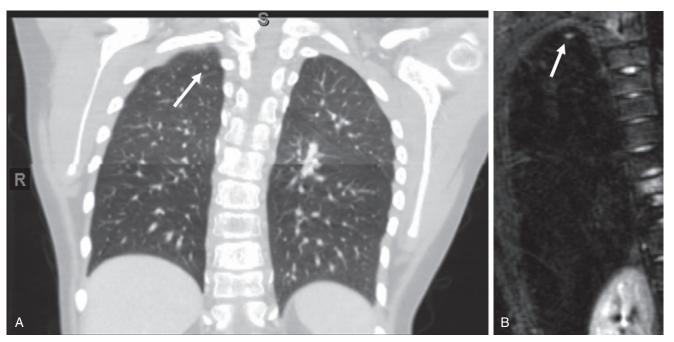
Eleven-year-old with metastatic rhabdomyosarcoma. A, Coronal CT image of the chest (lung window) demonstrates a 5.2-mm right upper lobe metastatic nodule (arrow). B, The same nodule (arrow) is hyperintense on a coronal short tau inversion recovery (STIR) image obtained 3 weeks later.
